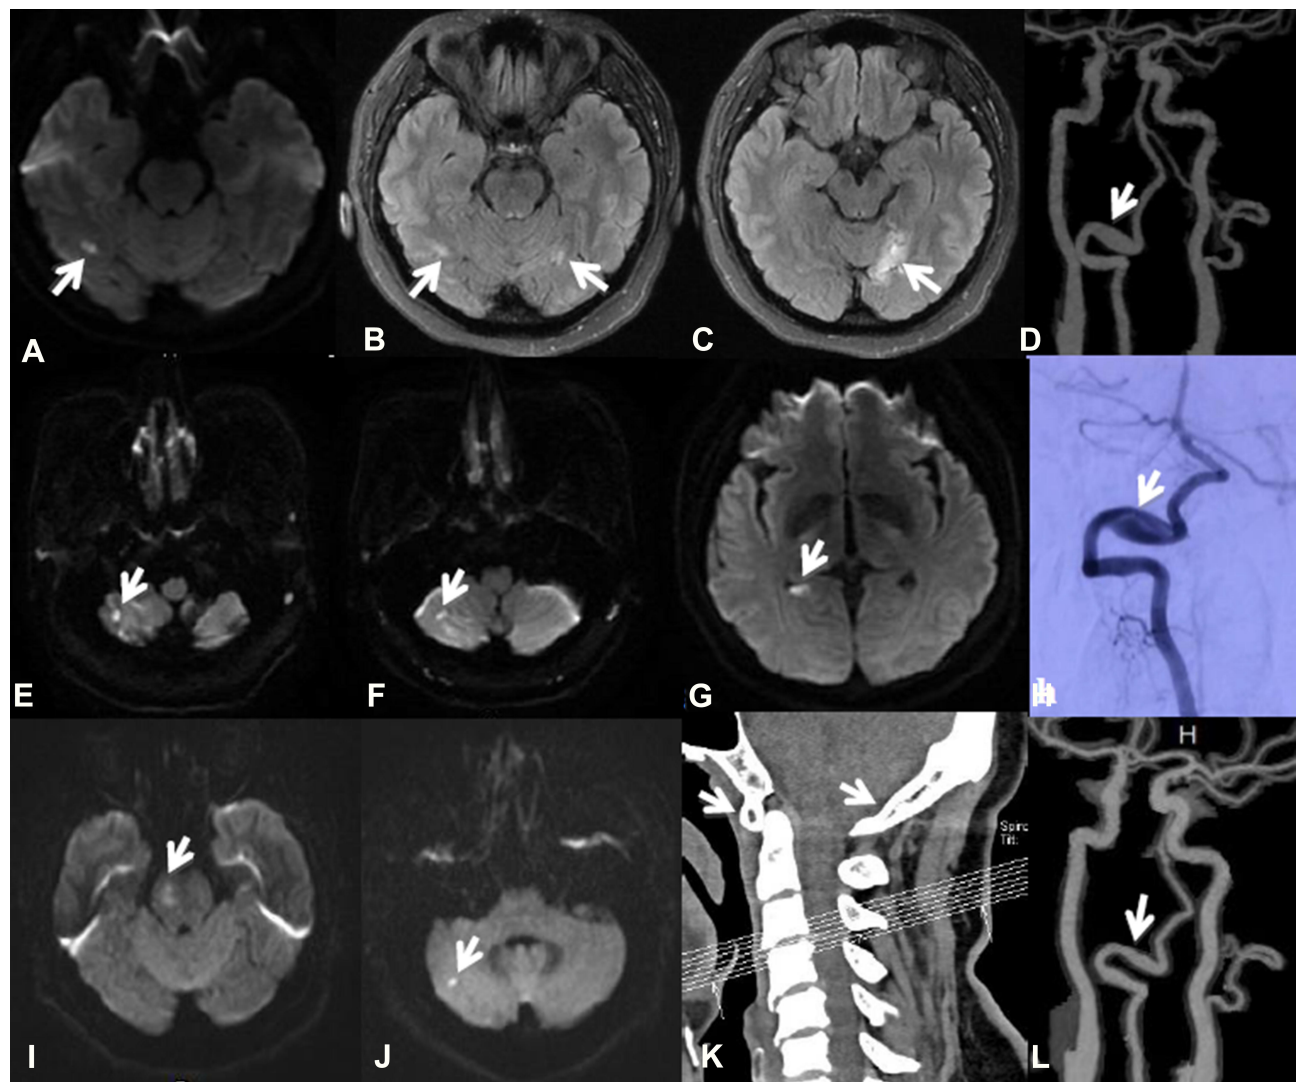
(A–C) Cranial MRI showing new infarcts at the right temporal occipital junction, with multiple old infarcts in the bilateral medial temporal occipital lobe and left thalamus (white arrow); (D) head CTA showing aneurysmal dilation on the V3 segment of the right VA (white arrow); (E–G) cranial MRI showing new infarcts in the right cerebellar hemisphere and right medial temporal lobe (white arrow); (H) DSA showing a dissecting aneurysm with a dual-lumen sign on the V3 segment of the right VA (white arrow); (I, J) repeat cranial MRI showing new infarcts in right cerebellar hemisphere and right pons (white arrow). (K) cervical CT scan showing atlanto-occipital fusion (white arrow); (L) repeat head CTA 7 months later revealing a smaller aneurysm on the V3 segment of the right VA (white arrow).
